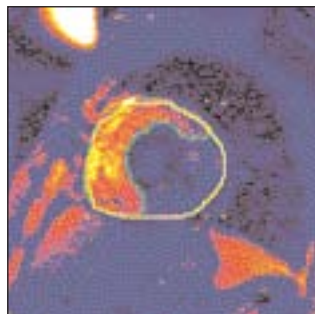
The MRI image of the left ventricle and the infarction size drawn with the image colour on hot metal (Courtesy of Universitas Hospital).
